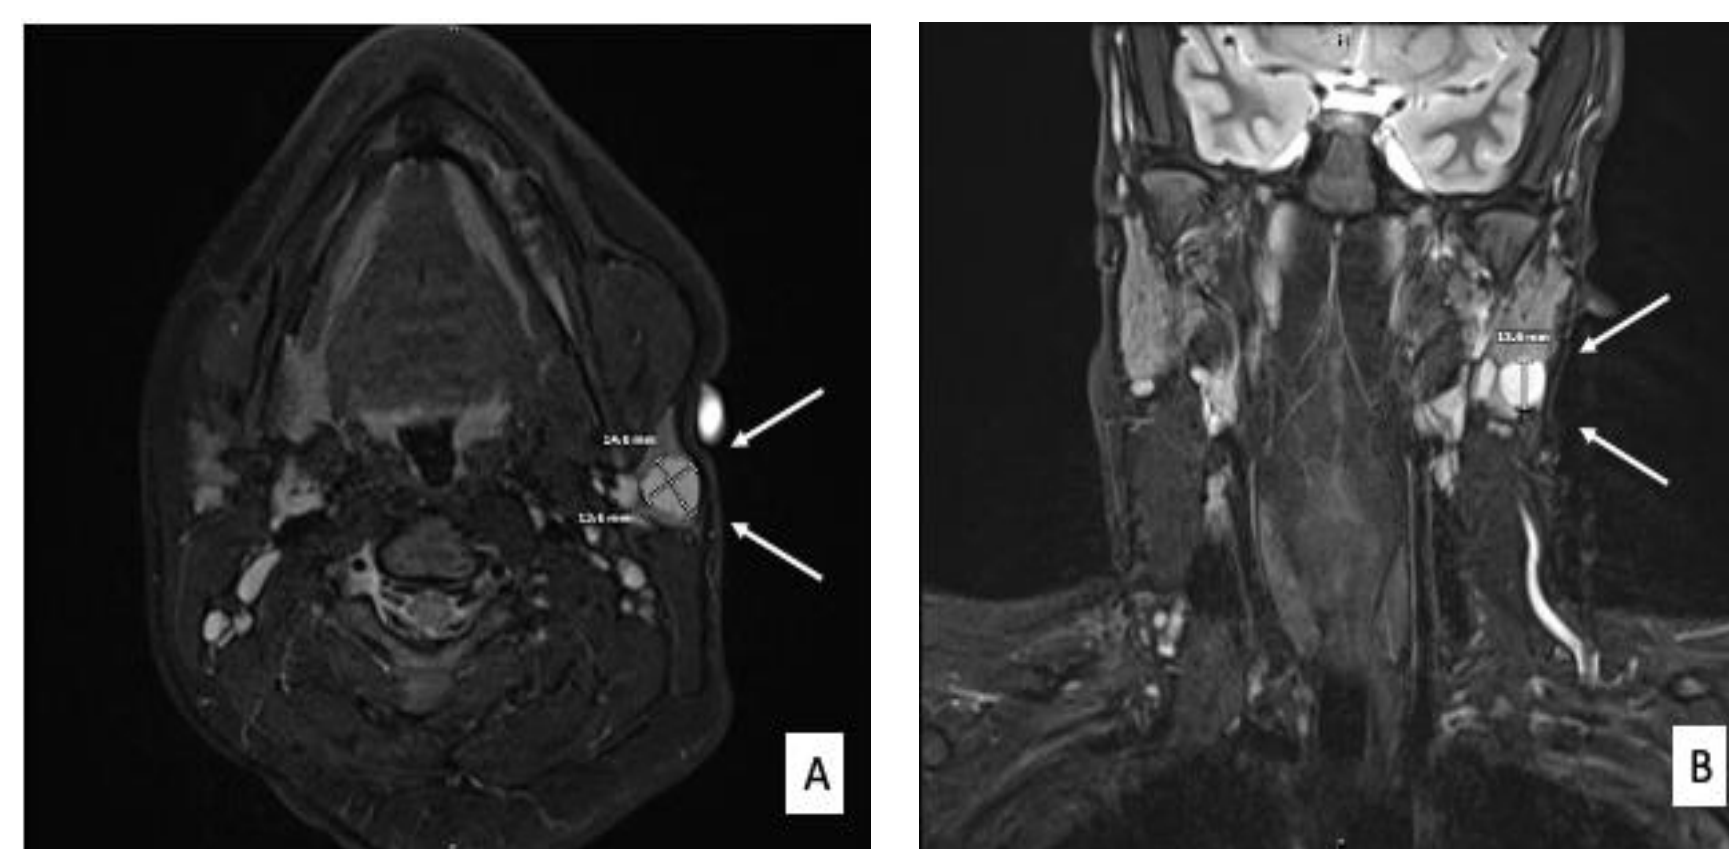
MRI neck with contrast in case 2. Axial (A) and coronal (B) images with white arrows indicating the left sided peri-parotid mass
